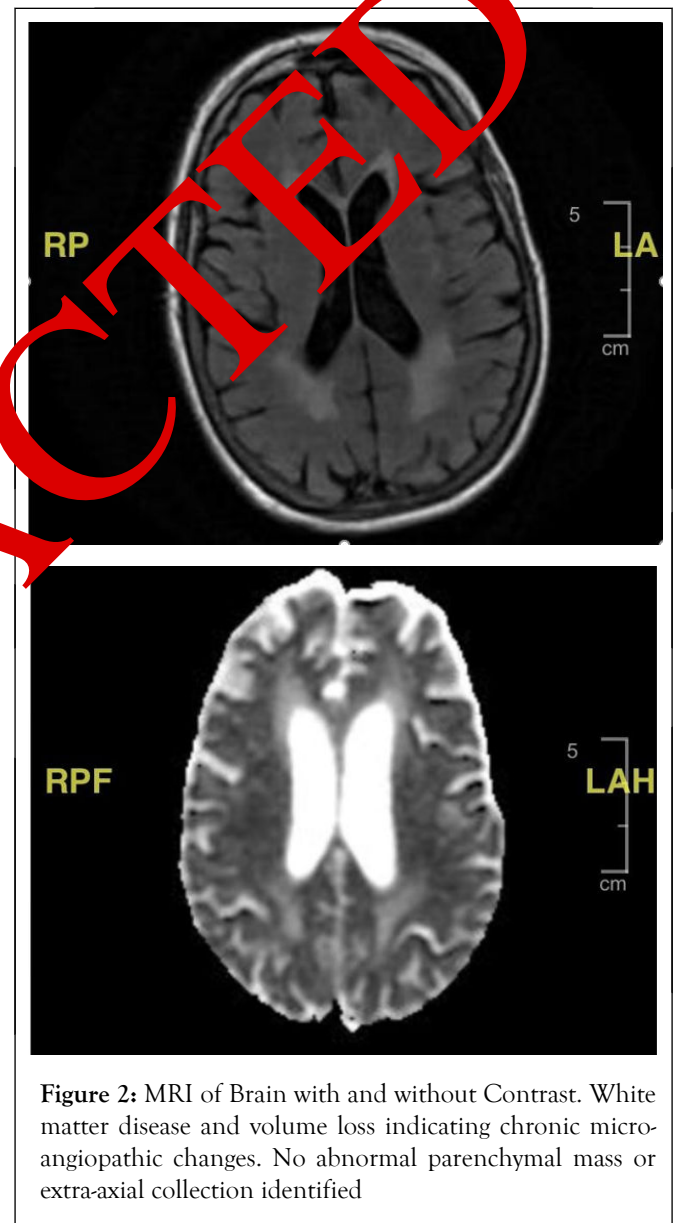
MRI of Brain with and without Contrast. White matter disease and volume loss indicating chronic microangiopathic changes. No abnormal parenchymal mass or extra-axial collection identified
